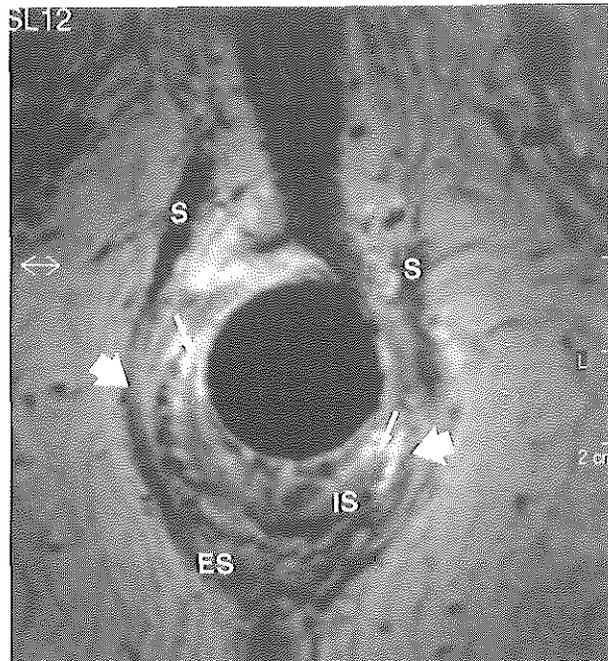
Endoanal MRI, axial proton density weighted GRE showing a complex lesion: external sphincter (ES) and internal sphincter (IS) defect (arrows), scarring (S) and asymmetry of the anal complex.
